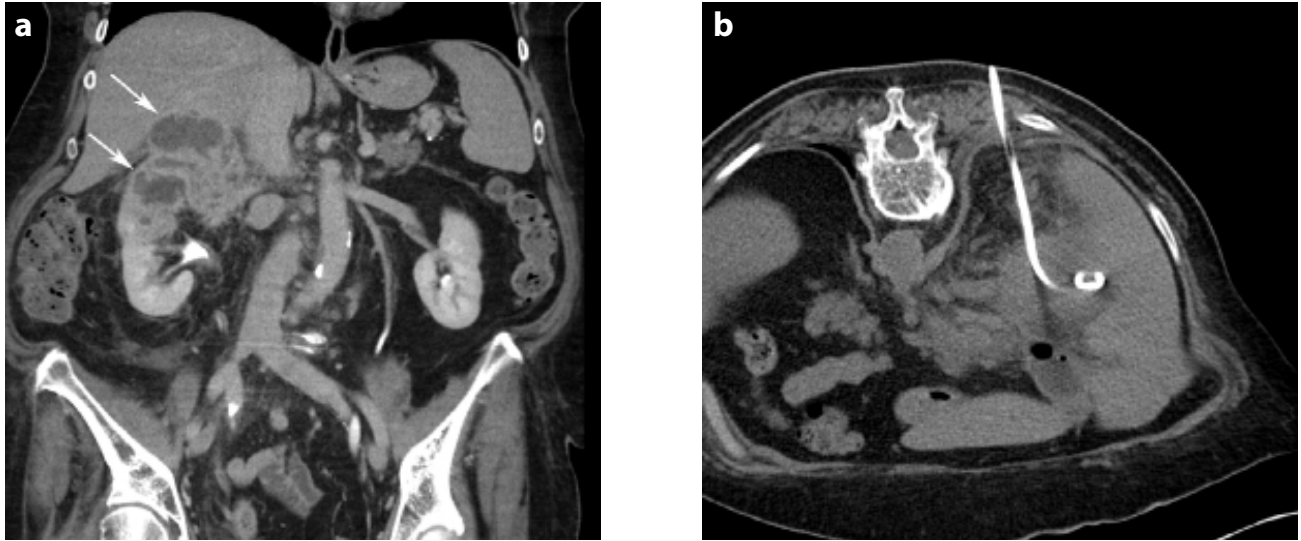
a MDCT in the coronal plane demonstrates a multiloculated abscess in the upper pole of the right kidney (arrows). There is contrast material present in renal pelvis. b CT-guided abscess drainage was performed in prone position.
